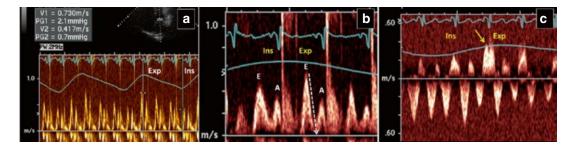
Constrictive pericarditis: Doppler findings. Panel a: Mitral inflow – Spectral Doppler recordings at the level of mitral leaflet tips with simultaneous respirometry demonstrates marked respiratory variations in the peak velocity of the mitral E wave. Note that the E wave velocity is lower during inspiration (*Ins*) beat than during expiration (*Exp*). Panel b: Mitral inflow – Spectral Doppler tracings at faster sweep rate demonstrates morphology of individual mitral inflow flow velocity pattern.
